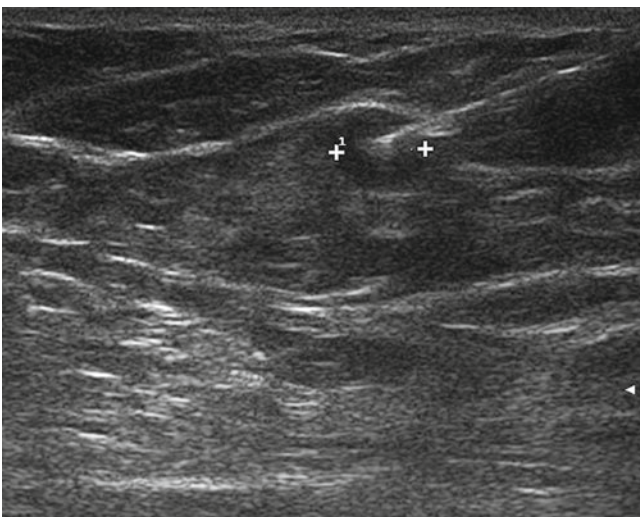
Presurgical guidewire. The wire is inserted into an in-transit nodule (4 mm, *calipers*) detected at the lateral aspect of the chest wall in a patient with abdominal wall primary melanoma on ultrasound before sentinel lymph-node biopsy
